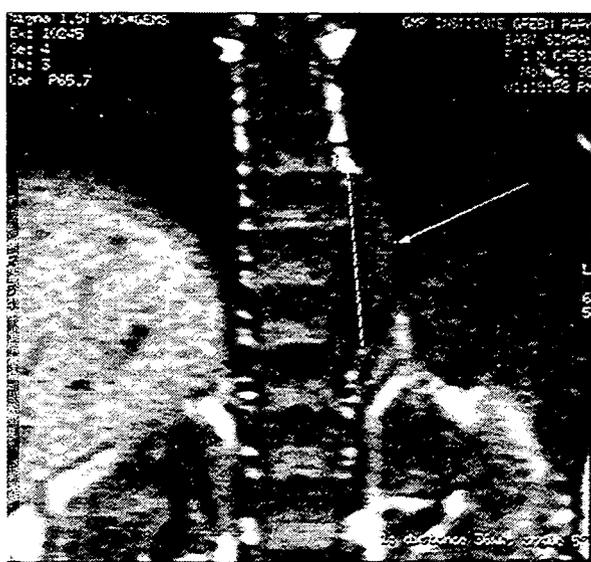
MRI image in coronal section showing a small mediastinal neuroblastoma
